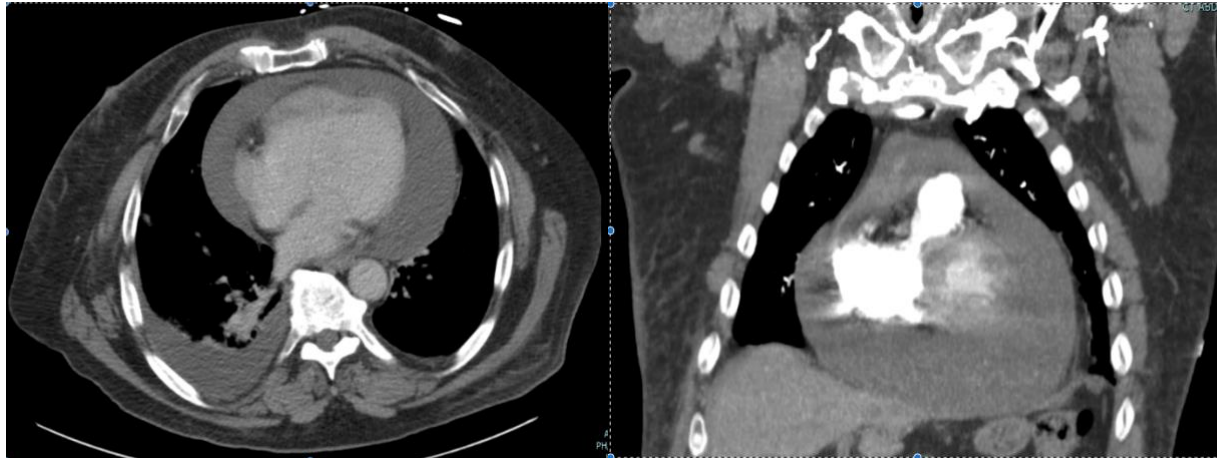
CT scan of chest showing marked pericardial effusion
